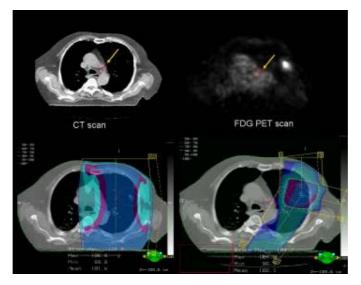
Lung cancer: target volume reduction after PET examination. On a CT scan (upper left) mediastinal lymph nodes appear enlarged (arrow) and are included in the treatment plan (bottom left). An FDG-PET scan, however, does not confirm such a finding, as no FDG uptake is detected (arrow). The target volume is therefore modified to exclude the mediastinal lymph nodes in the new treatment plan (bottom right).
